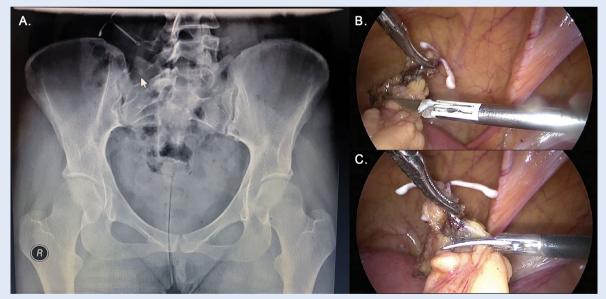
Perforated intrauterine device: A — the device marked with an arrow in the right iliac fossa; an abdominal X-ray; B — laparoscopic image of a perforated intrauterine device ingrown in the greater omentum next to the intestinal wall, C — laparoscopic removal of the intrauterine device
